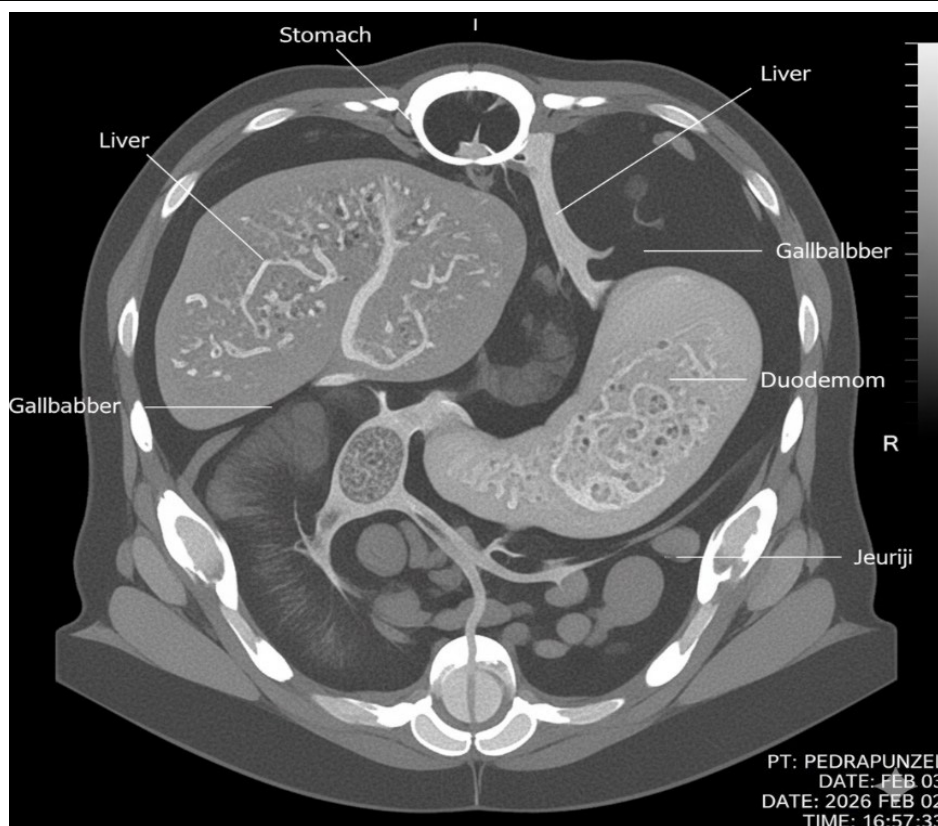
CT Abdomen (Rapunzel Syndrome with Gallbladder Extension)
